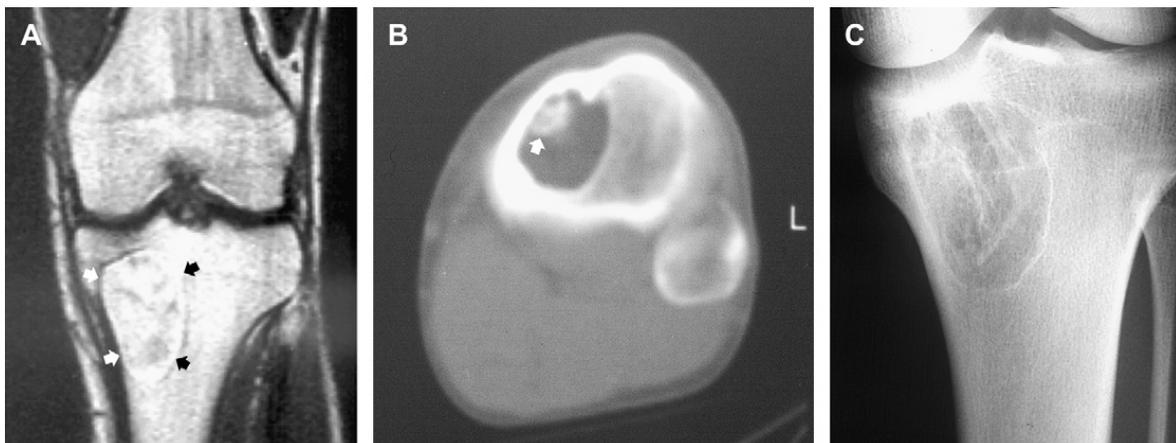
Intraosseous lipoma in the proximal tibia of a 22-year-old man. (A) Coronal T1-weighted (TR/TE; 600/32) spin-echo MR image shows an eccentric lesion in the tibial metaphysis (*black and white arrows*), extending into the epiphysis, with a signal intensity similar to that of the adjacent marrow. (B) Axial CT scan shows the lesion to have an attenuation similar to that of the adjacent subcutaneous adipose tissue. Note delicate ossification within the lesion (*arrow*). (C) Corresponding anteroposterior radiograph shows a geographic lytic lesion with a sclerotic margin, eccentrically located in the metaphysis extending into the epiphysis.
